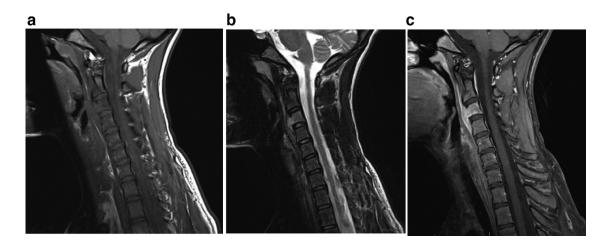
MRI with and without Gadolinium enhancement with TSE T1 (A), T2 Dixon (B), and T1 Dixon postcontrast (C) sequences. There is enhancement marrow signal alteration in the C3 vertebral body with breakthrough into the prevertebral space. No canal involvement is noted.
